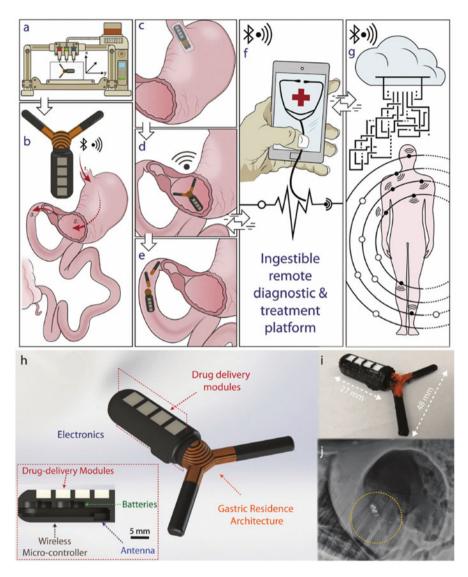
3D-printed gastric resident electronics (GRE) (Labels: (a) patient-specific 3D printing, (b) designed GRE for oral delivery, (c) compressed into a capsule form, (d) device expansion activates gastric residence and offers wireless communication, (e) disintegration of the device, (f) compatible with smart phone, (g) interconnection with other electronics devices, and implants for responsive medication, (h) computer-aided design models of the GRE, (i) optical photograph of a fabricated device, and (j) X-ray image of deployed GRE stomach [48]
